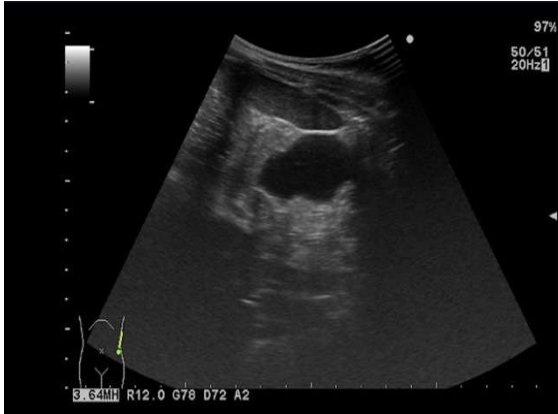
Ultrasonography at age of 8-month. Grade IV left hydronephrosis with 7-8 mm renal parenchymal thickness are revealed.
